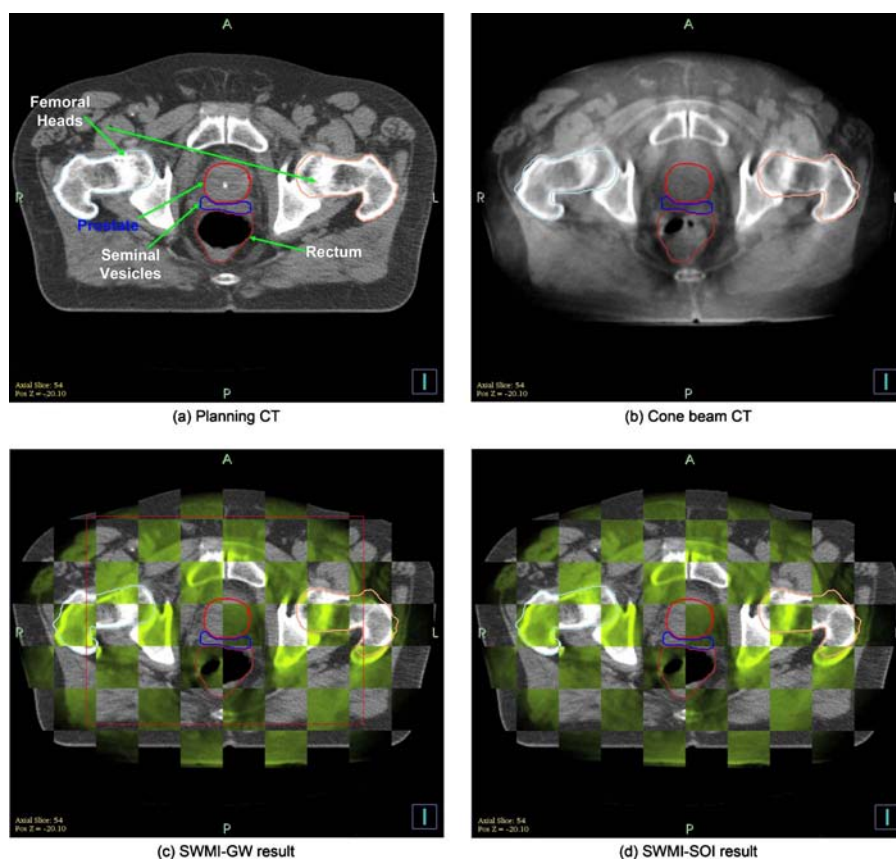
Image registration result for a prostate patient. (a) Planning CT with the ROI overlaid. (b) A cone beam CT of 36th day after the planning CT is acquired. (c) The registration result of SWMI-GW with the weight centered at beam isocenter. The rectangular box shows the $\pm 2\sigma$ boundary for SWMI-GW registration. (d) The result of SWMI-SOI registration.
